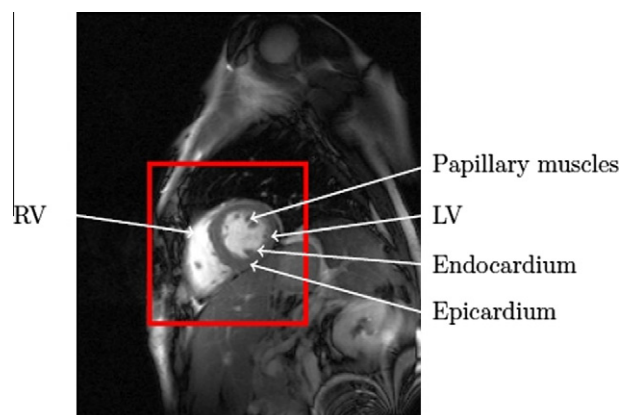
A full size short-axis cardiac MR image and a ROI identifying the heart.
